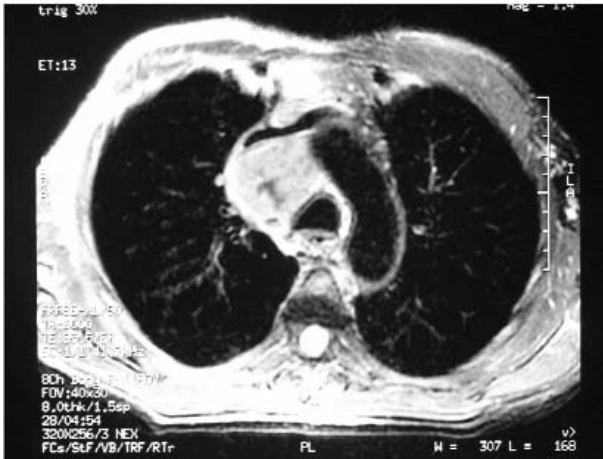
MRI demonstrating the close relationship to mediastinal structures.
